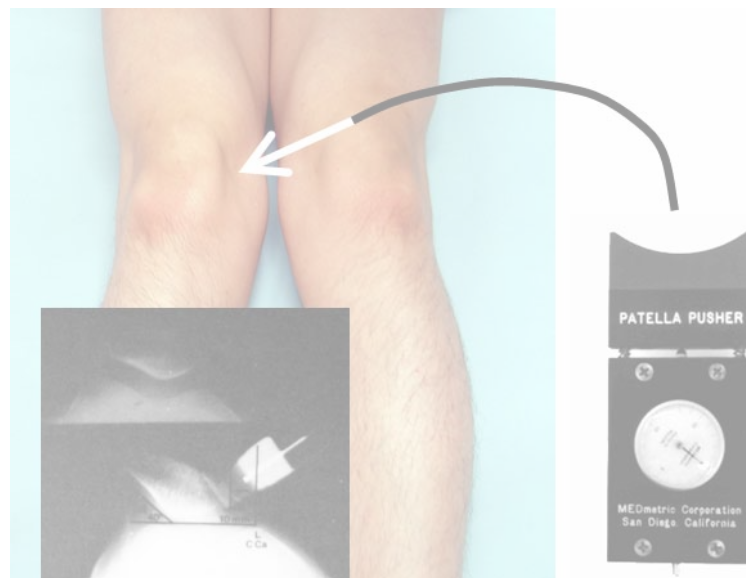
Axial stress x-ray of patellofemoral joint. The patella being displaced by a force dynamometer (patella pusher), the displacing force was in both horizontal and downward directions. X-ray image from Minkoff & Fein (1989) with permission.
